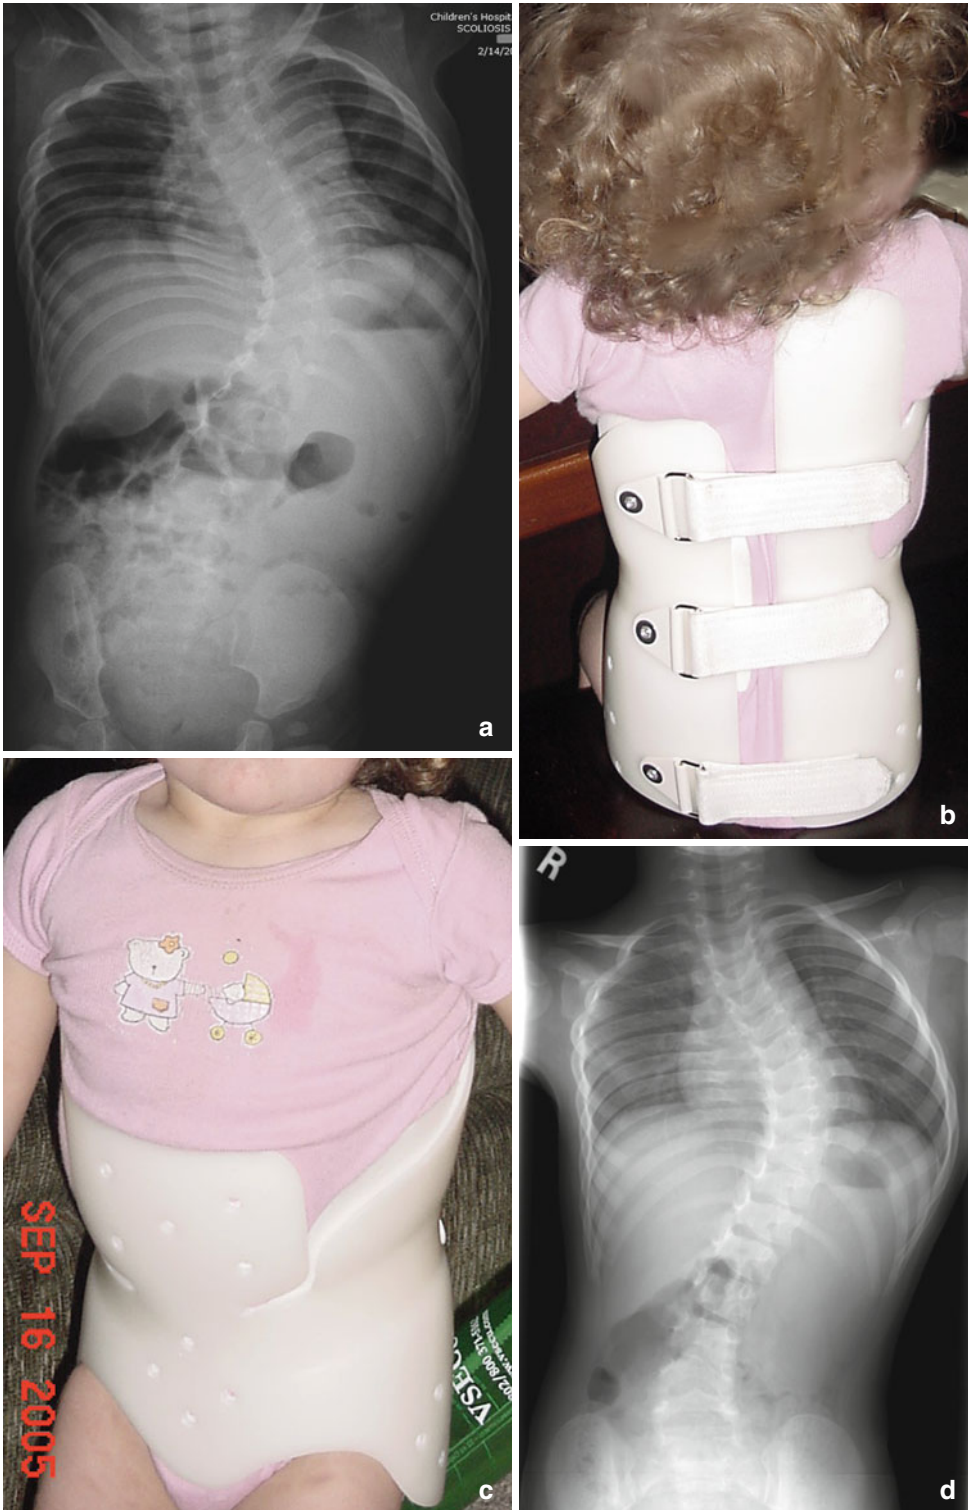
EOS with tethered spinal cord. Scoliosis noted at the age of 6 months. No treatment was initiated and no MRI was done until the age of 2 years. In spite of detethering performed at the age of 2 years, scoliosis progressed at the age of 2 1/2 years (a) and bracing was initiated. Full-time
